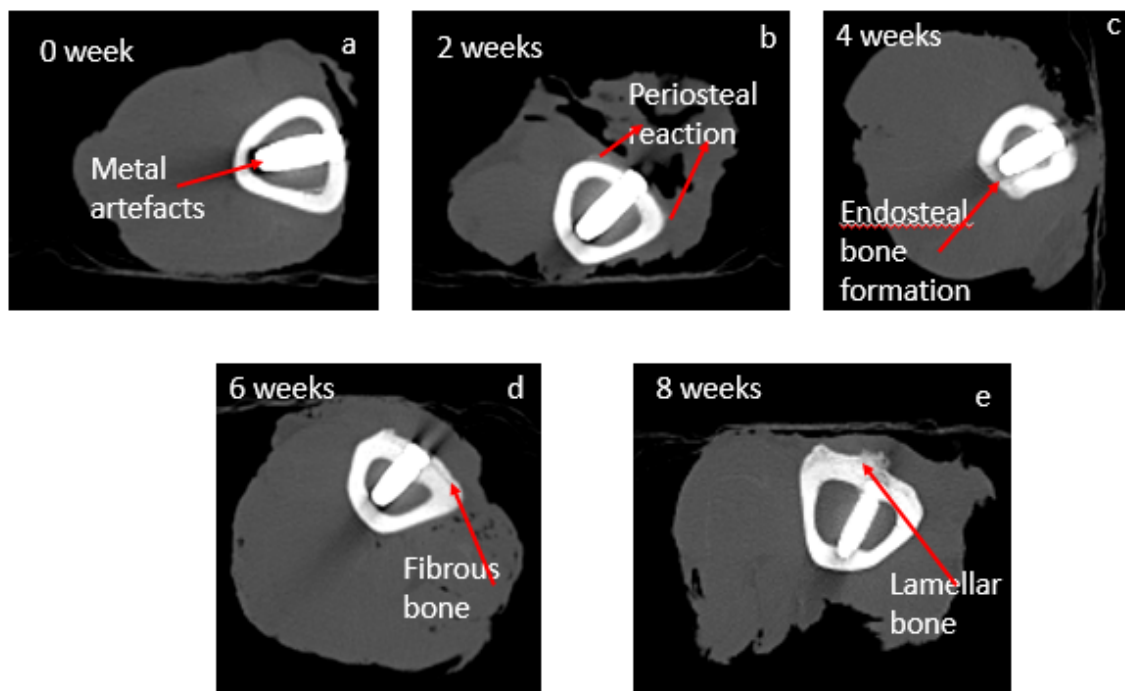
Conventional CT images displaying different stages of bone healing at the bone-metal interface.
